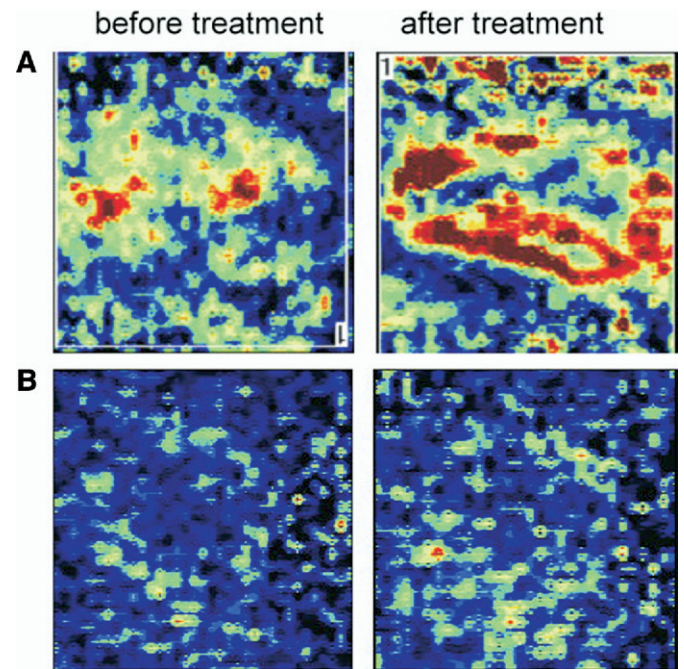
Laser Doppler scan showed significant increase in blood flow perfusion after ESWT (A), whereas the changes were not significant after HBO (B).
